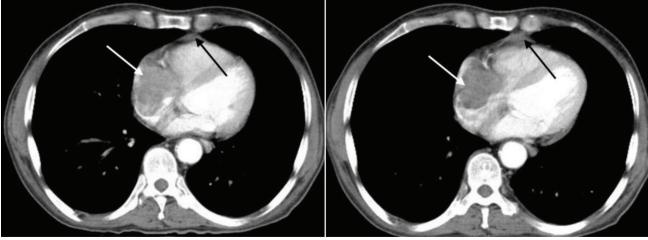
Two consecutive CT images with contrast administration show a filling defect in the right atrium (white arrows) that is a metastatic lesion. There is mild pericardial effusion (black arrows).
